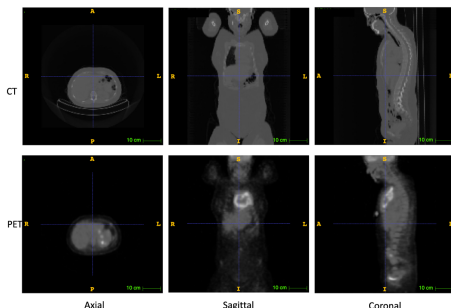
Example of PET-CT Lymphoma Image
